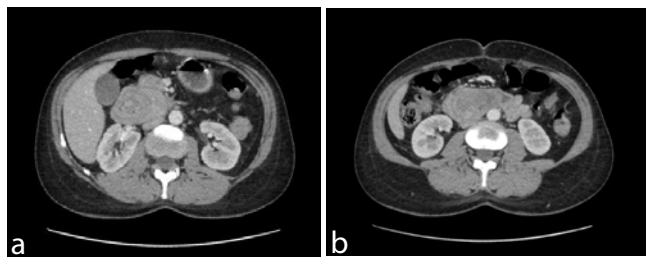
Abdominal computed tomography showing the mass without distant lesion.
